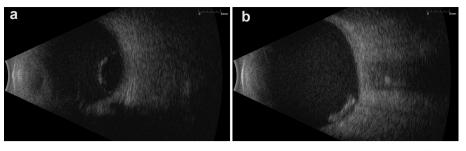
a B-scan ultrasonography of the involved eye in Case 1 showing a hyperechoic outline of the posteriorly dislocated crystalline lens. b B-scan ultrasonography of the involved eye in Case 2 showing an inferior hyperechoic linear structure representing the dislocated intraocular lens/bag complex.
